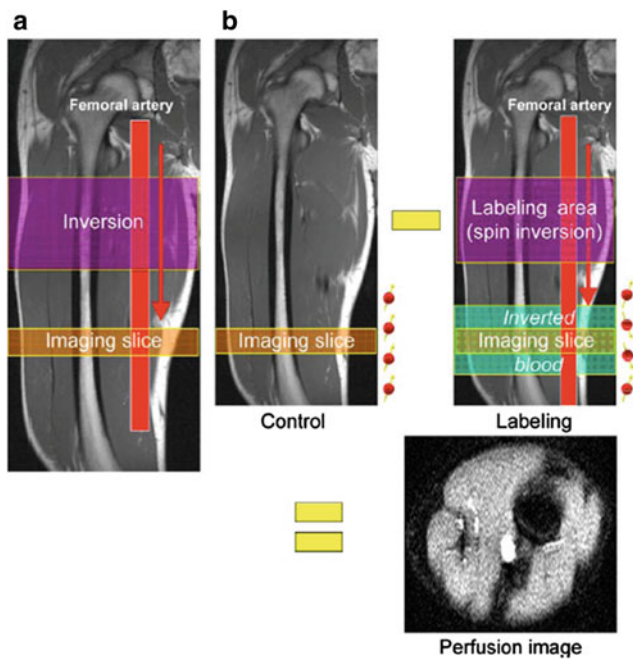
Principle of ASL MR perfusion imaging. a In ASL MRI, blood serves as intrinsic contrast agent. For this, blood is magnetically labeled by an inversion pulse outside the imaging slice and then flows, depending on the blood flow, into the imaging slice. b The difference between the MR image with and the MR image without labeled blood yields an image with signal only from inflowing blood, whereas background signal is suppressed. This image is the perfusion weighted ASL image. From Weber et al. (2007). This material is reproduced with permission of Springer
